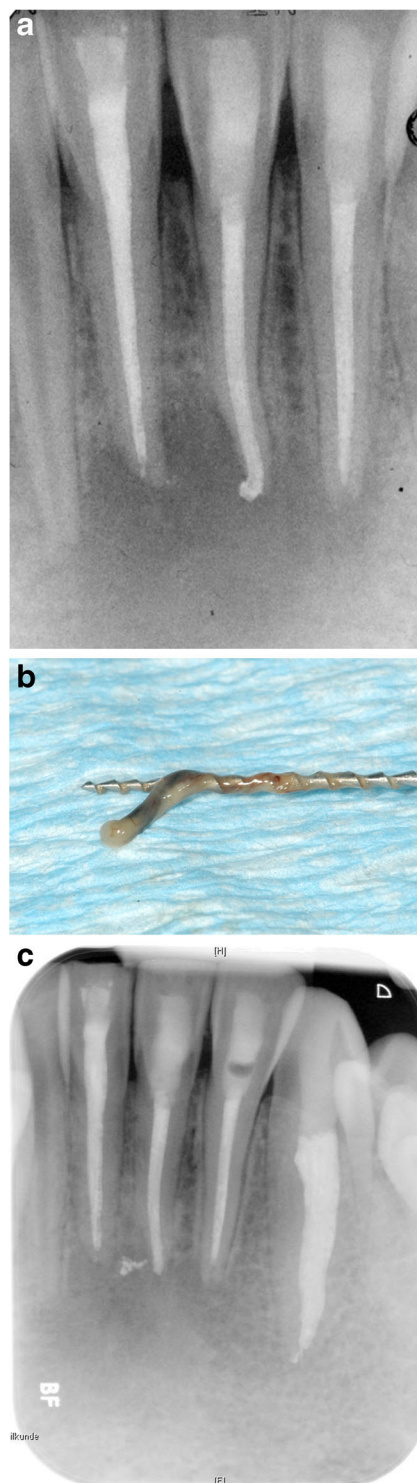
a Radiograph taken immediately after root canal obturation of teeth 32, 31 and 41 (same patient as in Fig. 4). b During root canal treatment, ischemic and non-vital pulp tissue was removed. c Radiograph taken at the 1-year follow-up showing that healing of the periradicular tissues was in progress. The patient was free of pain, but meanwhile, also tooth 33 required root canal treatment
